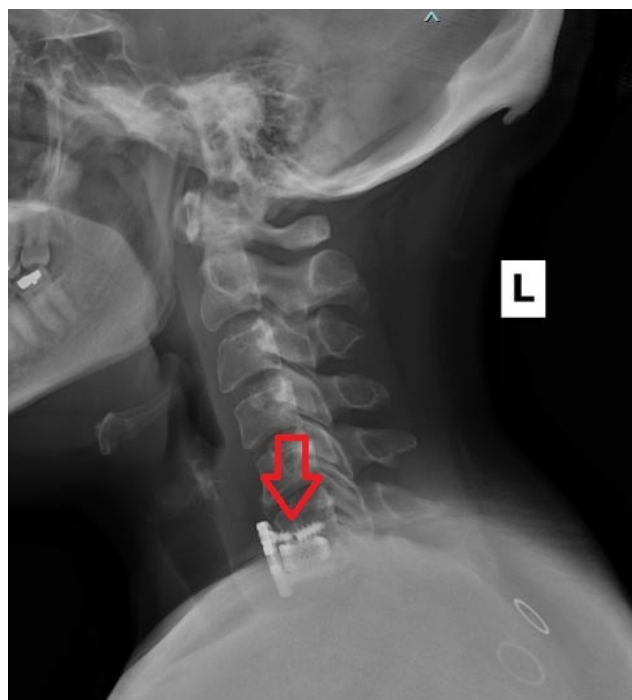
Lateral cervical spine X-rays showing fractured hardware
